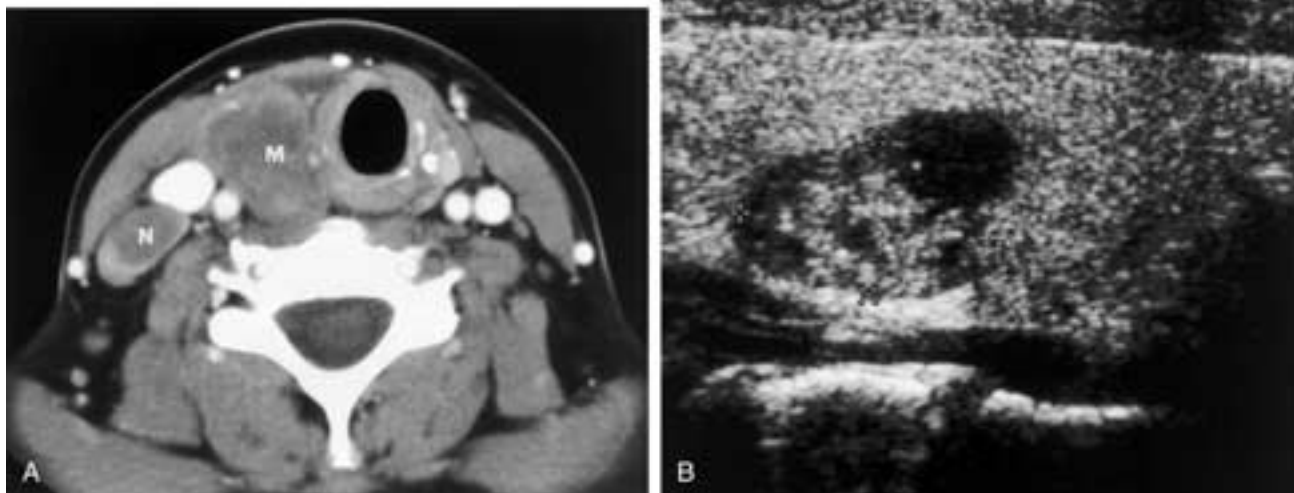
Papillary thyroid carcinoma in two different patients. A, Enhanced axial CT scan shows a dominant hypodense mass (*M*) replacing the right lobe of the thyroid gland. Also note the pathologic ipsilateral cervical lymph node (*N*). B, A sagittal sonogram of the right lobe of the thyroid shows a dominant nodule with heterogeneous echogenicity. There are both cystic and frond-like solid components. (Courtesy of Dr. Jill Langer, Department of Radiology, Ultrasound Division, University of Pennsylvania Medical Center.)
